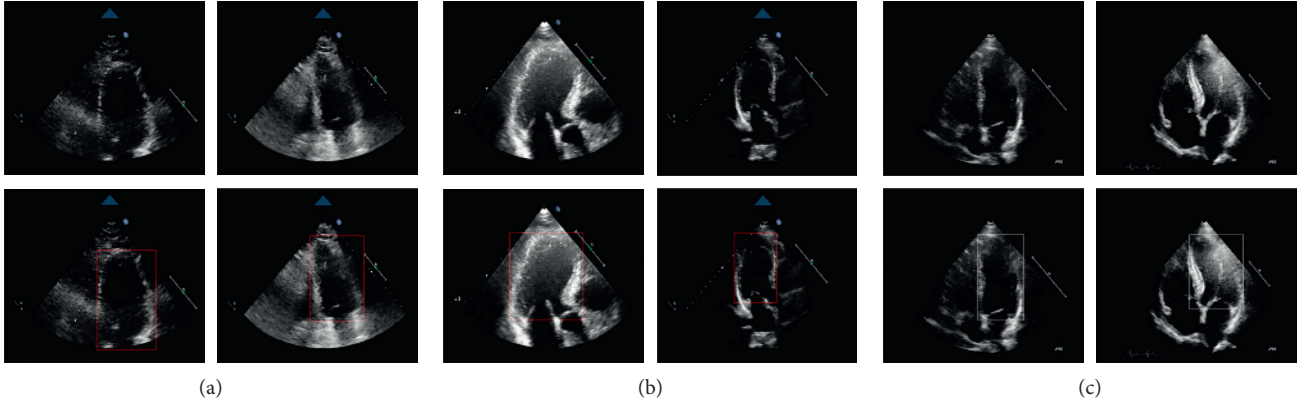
The first row shows the original echocardiography images, and the second row shows the images with left ventricle region annotations. (a) A2C images. (b) A3C images. (c) A4C images.
